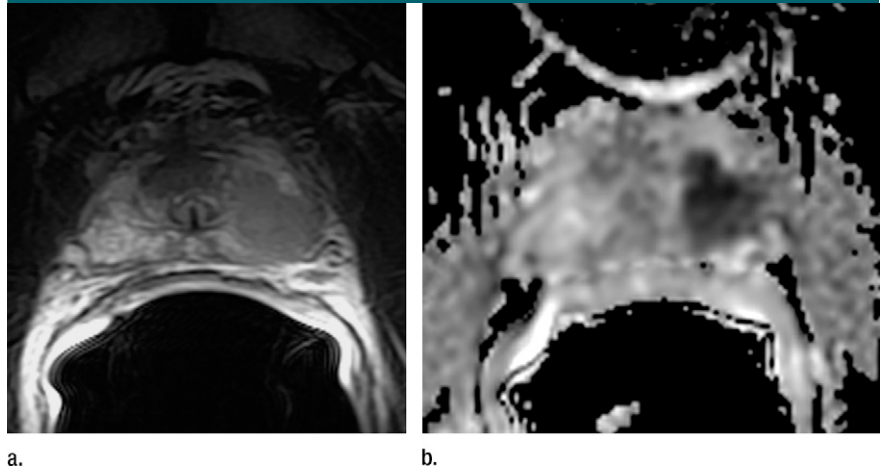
Gleason score 7 (4 + 3) tumor of the left prostatic apex in a 65-year-old patient is seen as (a) a homogeneous focus of low signal intensity on a transverse T2-weighted MR image (3516/122) and (b) a focus of restricted diffusion on the ADC map (3500/76.3; *b* value, 700 sec/mm²).
